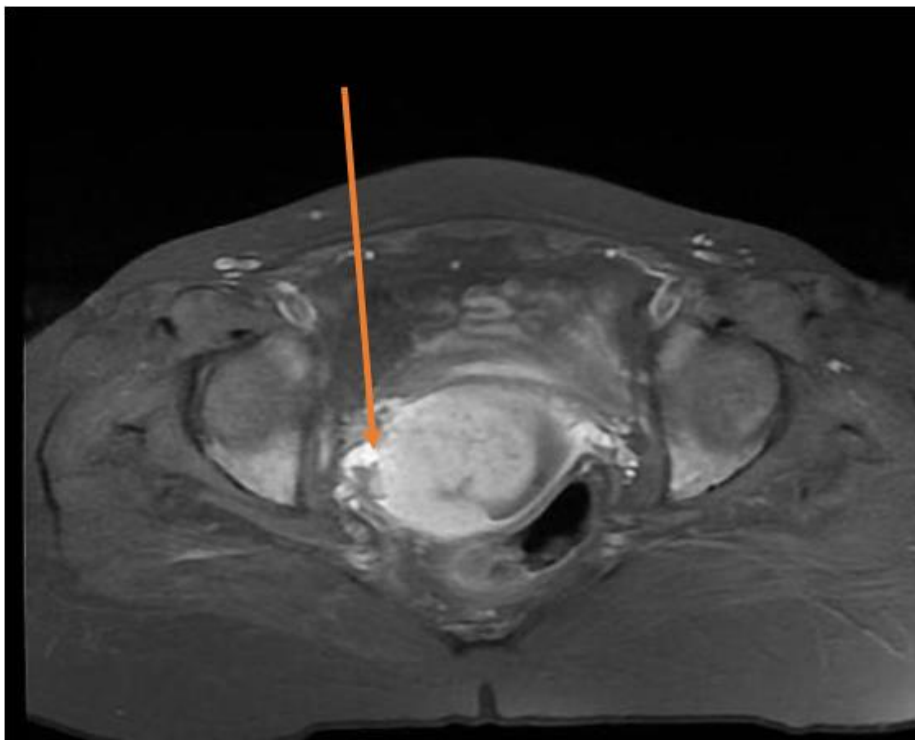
Cervical cancer invading the parametrium on the right side. Axial pelvis MRI T1 C+ fat sat
